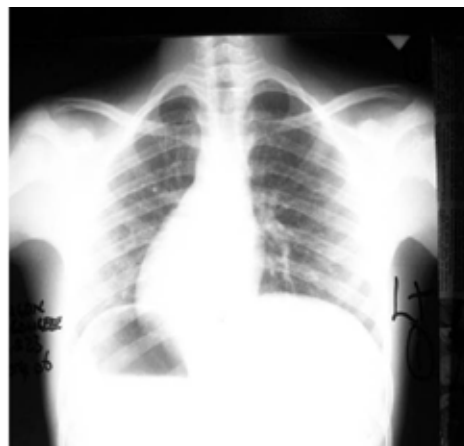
A properly oriented chest X-ray in figure 1 showing dextrocardia and situs inversus.
